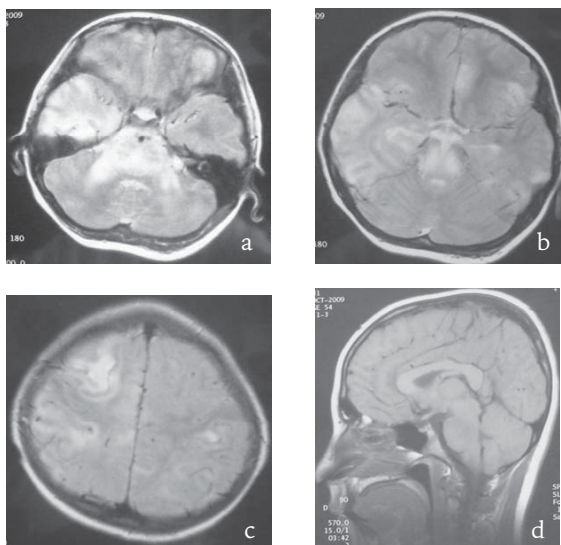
Axial T2-weighted magnetic resonance images show high signal in the pons extending to middle cerebellar peduncles and right temporal lobe (a) and mesencephalon (b), and more pronounced on the right hemisphere, in the cortical and subcortical white matter in the cerebrum (c). Sagittal T1-weighted image shows low signal in the pons (d).
